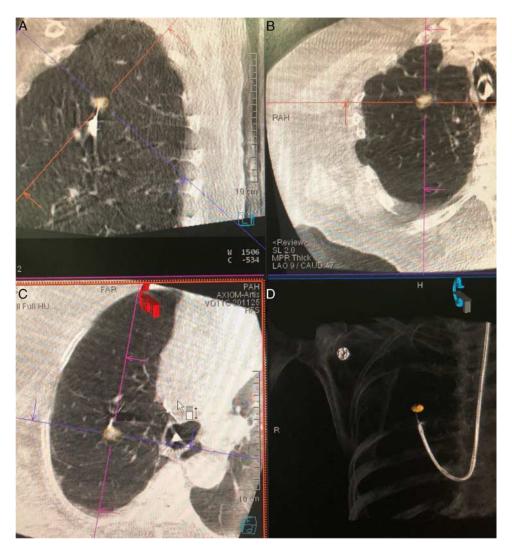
Cone-beam computed tomography–derived augmented fluoroscopy used during diagnostic bronchoscopy of a non-small cell lung cancer. Cone-beam computed tomography tool-in-lesion view with needle seen entering nodule from sagittal (A) and axial views (C). Segmenting the lesion in axial view after the initial intraprocedural cone-beam computed tomography scan (B). Augmented fluoroscopy used as live guidance during biopsy maneuver (D).
